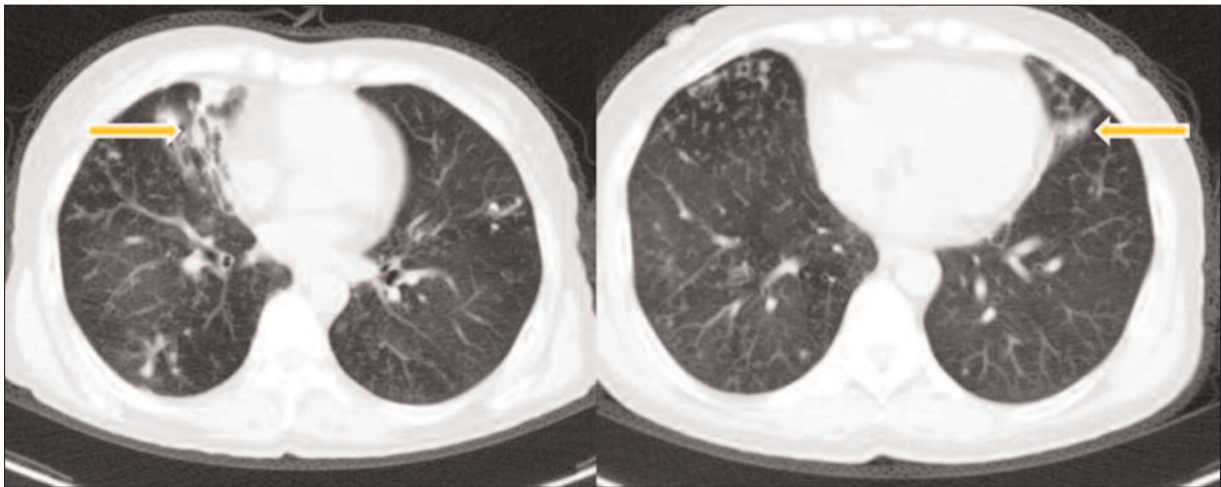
Chest CT scan demonstrates right middle, left lingual segment bronchiectasis in the 49-year old women with *Mycobacterium intracellulare* induced lung infections.
